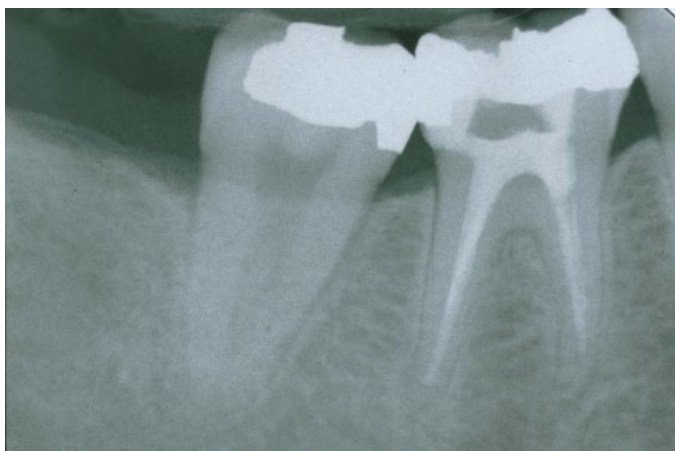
(A) Periapical radiograph showing tooth #30 after successful root canal treatment.
